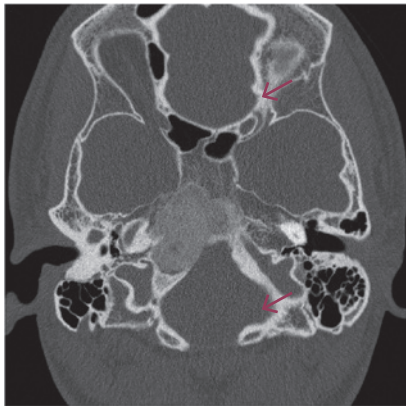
typical ground glass appearance of fibrous dysplasia on CT.
